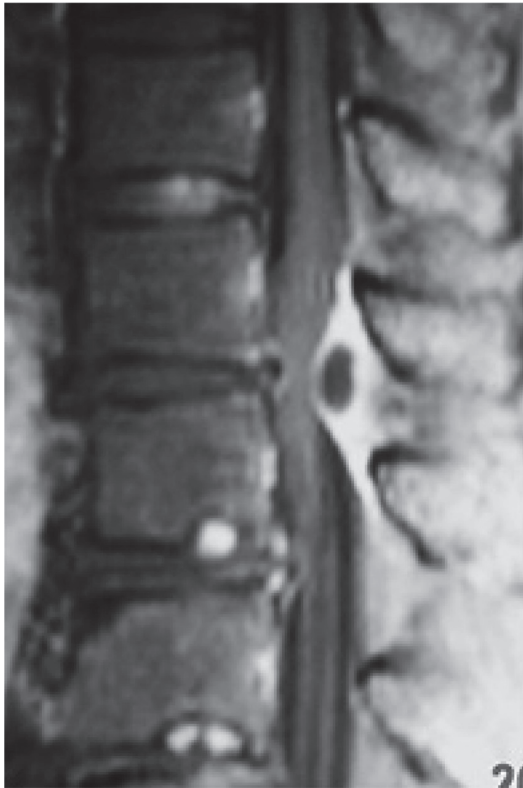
Magnetic resonance imaging of gadolinium-enhanced T1-weighted image of a patient with amyloidoma (case 13).
